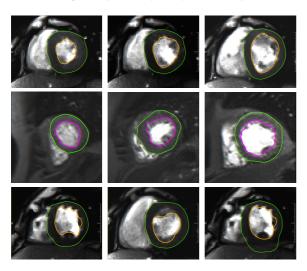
Top: cine MRI segmentation; Middle: MIP perfusion data segmentation; Bottom: limitation are papillary muscles very close to the myocardial wall and no contrast between myocardium and liver.
